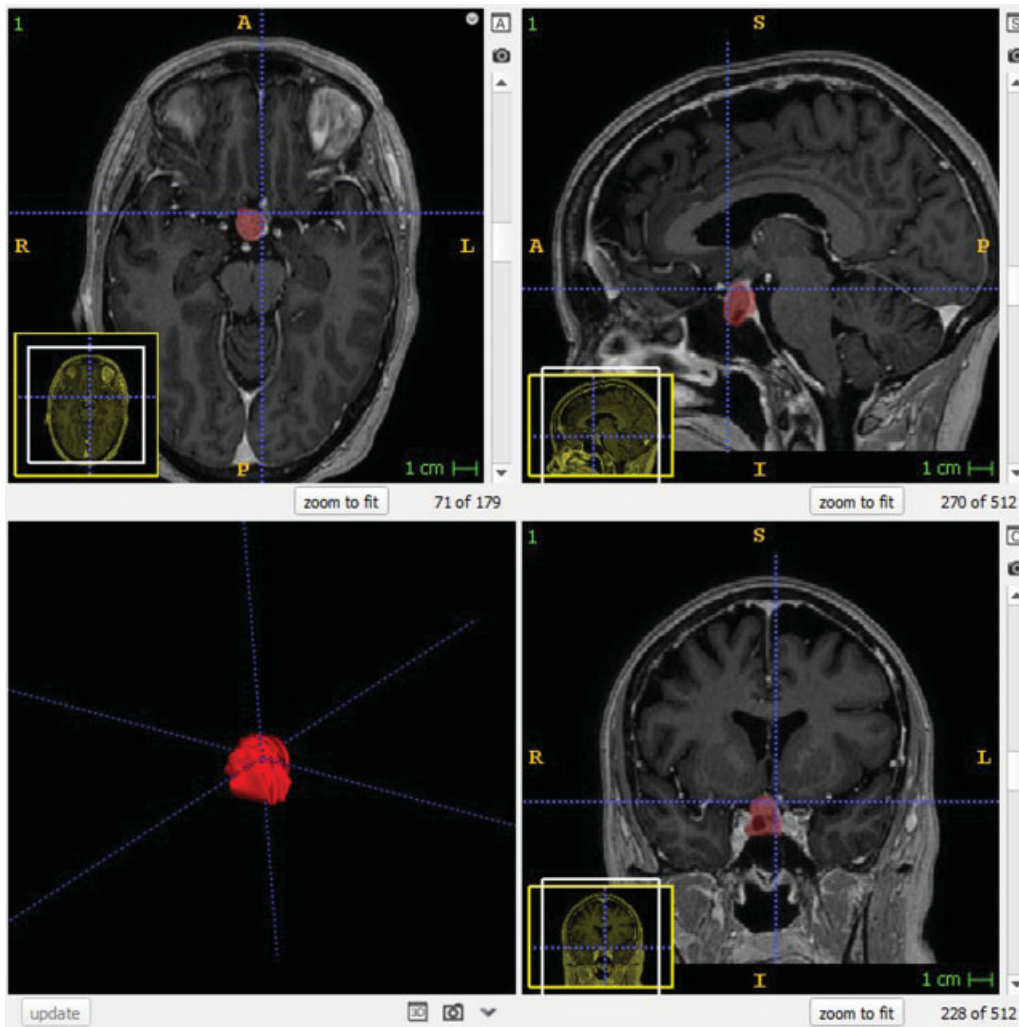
View of three-dimensional segmentation of a pituitary tumor. The tumor is marked in red on axial (upper left), sagittal (upper right), and coronal views (lower right) on magnetic resonance images.
